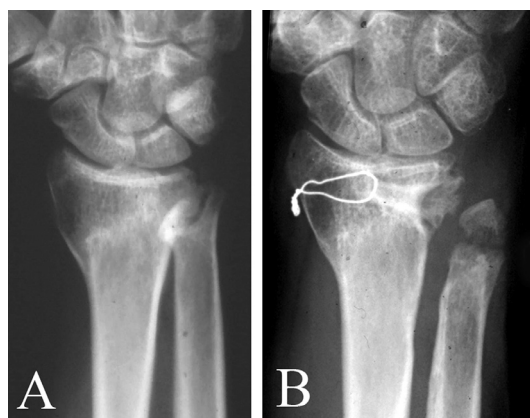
Case 2. A 51-year old female. (a) Preoperative x-ray. (b) X-ray 13 months postoperatively. The graft with vascular failure has partly absorbed. No healing between MT-head and ulna.
